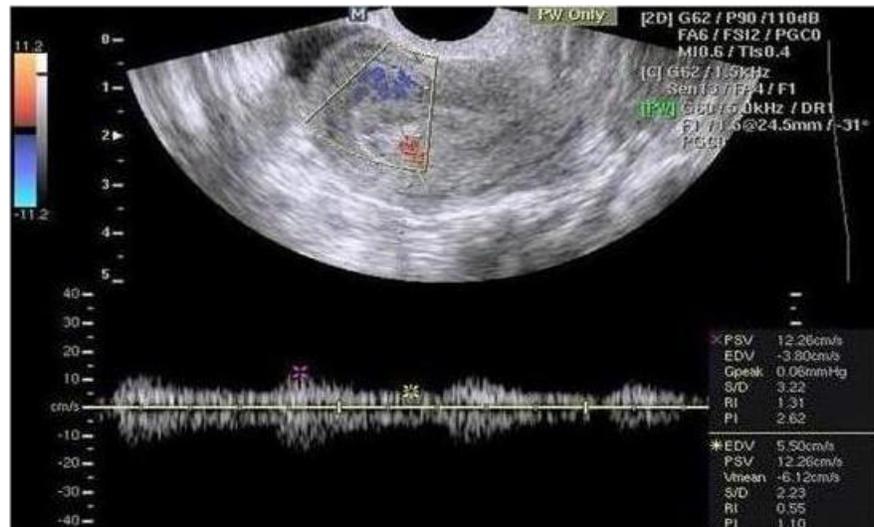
Doppler ultrasound velocimetry in Fertile group
